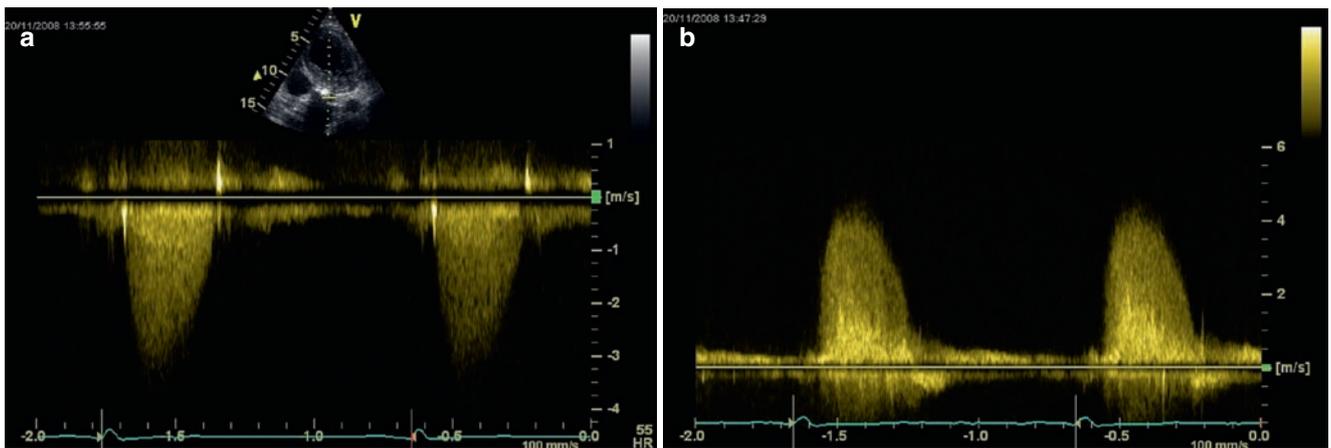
CW Doppler recordings of a patient with severe AS: the recording from the apical window provides a peak velocity of 3.4 m/s consistent with moderate AS (a), whereas the right parasternal window provides 4.3 m/s consistent with severe AS (b), emphasizing the importance of the use of multiple transducer positions
